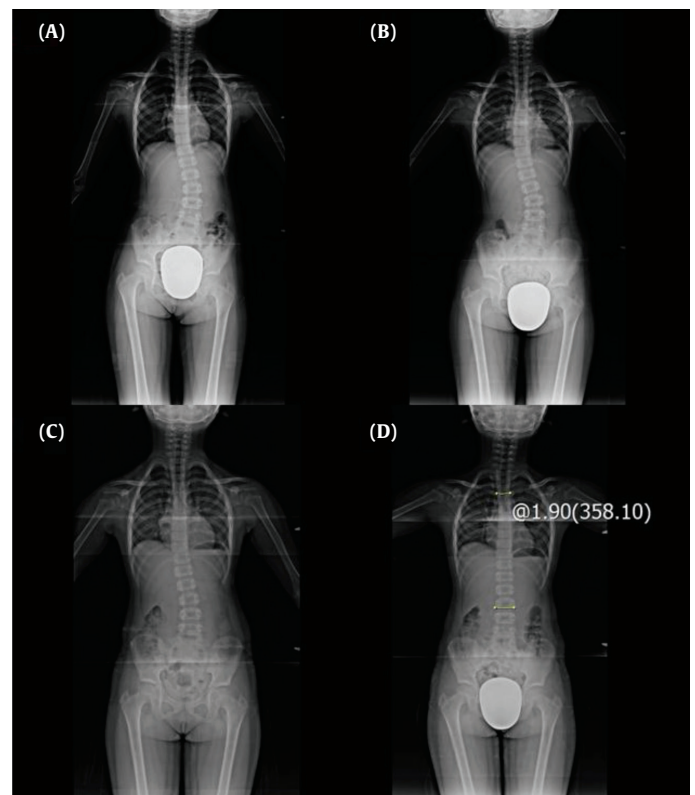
Radiograph images during the 5-month course of treatment. (A) 2015.08.18, (B) 2015.09.04, (C) 2015.10.16, (D) 2015.12.18 (Cobb angle: 1.90°).
